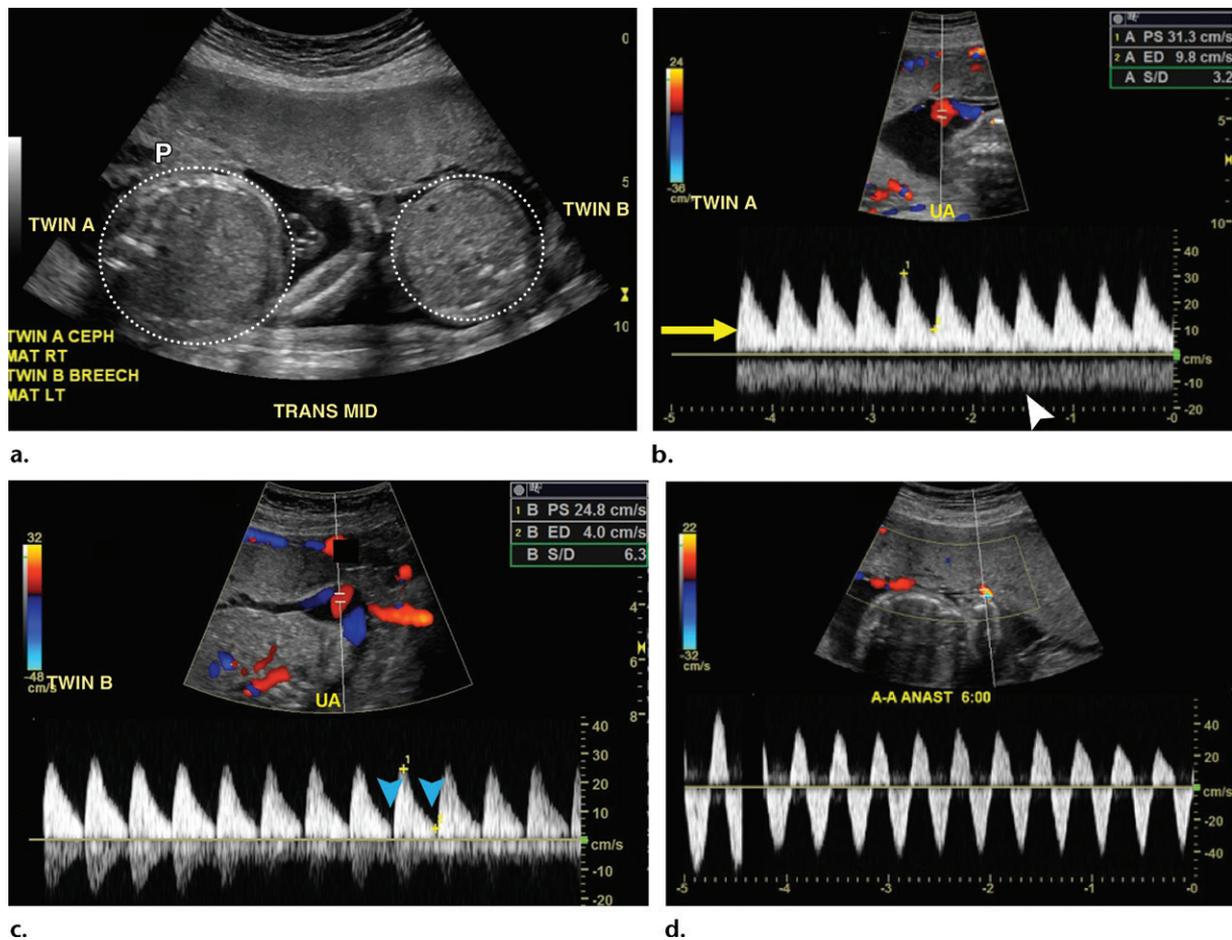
MC-DA twin pregnancy with unequal placental sharing. (a) US image shows MC-DA twins (dotted circles) with a single shared anterior placenta (*P*). Visual discrepancy in the size of the twins is evident. A 30% weight discordance was determined. The smaller twin, twin B, has a velamentous cord insertion, which is a known risk factor for size discordance between twins. *CEPH* = cephalic, *MAT* = maternal, *LT* = left, *RT* = right, *TRANS MID* = transverse middle. (b) US Color Doppler image shows a twin with a normal umbilical artery (*UA*) waveform, with forward diastolic flow (arrow). Normal antegrade umbilical vein flow is present without pulsatility (arrowhead). *ED* = end-diastolic velocity, *PS* = PSV, *S/D* = systolic to diastolic ratio. Keys are the same for Figure 21c. (c) Color Doppler US image shows occasional loss of end-diastolic flow (arrowheads), sometimes diagnosed in the setting of an arterial-arterial anastomosis. (d) US Doppler image of the placental surface shows an arterial-arterial anastomosis (*A-A ANAST*) with to-and-fro flow. To visualize arterial-arterial anastomosis, search along the placental surface with color Doppler US for possible vessels with aliasing. Spectral interrogation of this focus should be pursued to evaluate for to-and-fro flow.
